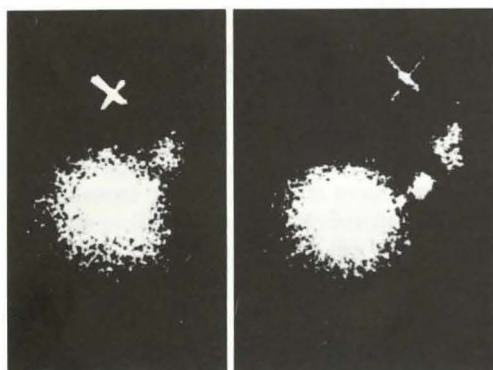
Left: scintigram (frontal view) of the injected bolus of ^{99m}Tc antimony colloid and visualized lymph node after mastication. Right: The same condition with the head in the right oblique position. The visualized lymph nodes are now in proper distance from the main bolus. X: indicates jugulum.
